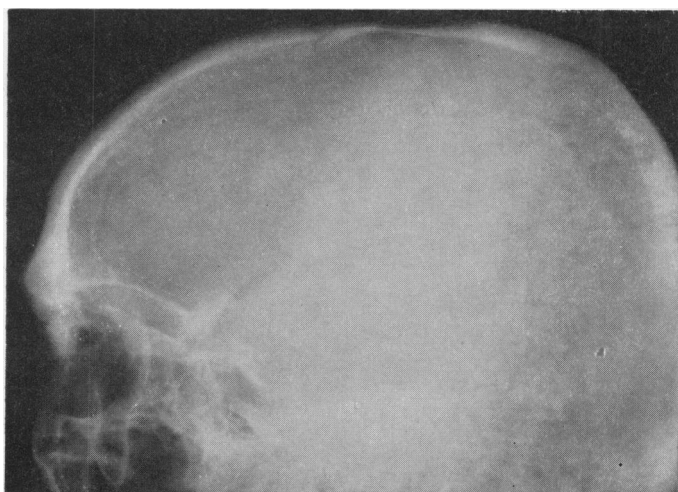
Skull deposit became stationary one month after changing to testosterone and by three months was smaller. Complete healing occurred and lasted until death. Radiograph 38 months after beginning testosterone.
